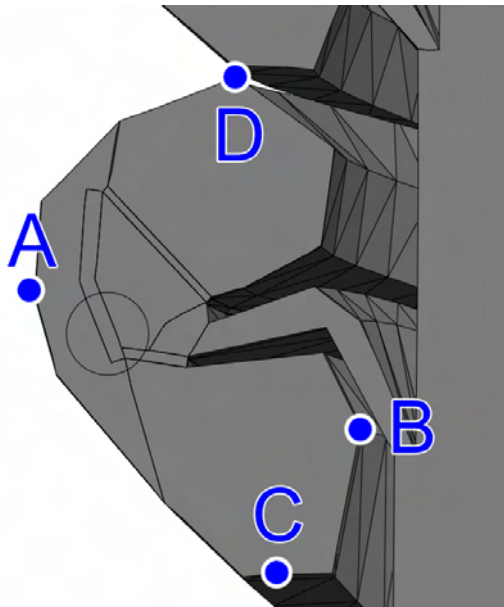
A slice through the model at the angle of the electrode. Markers were placed in the same manner as the μ -CT slice.
